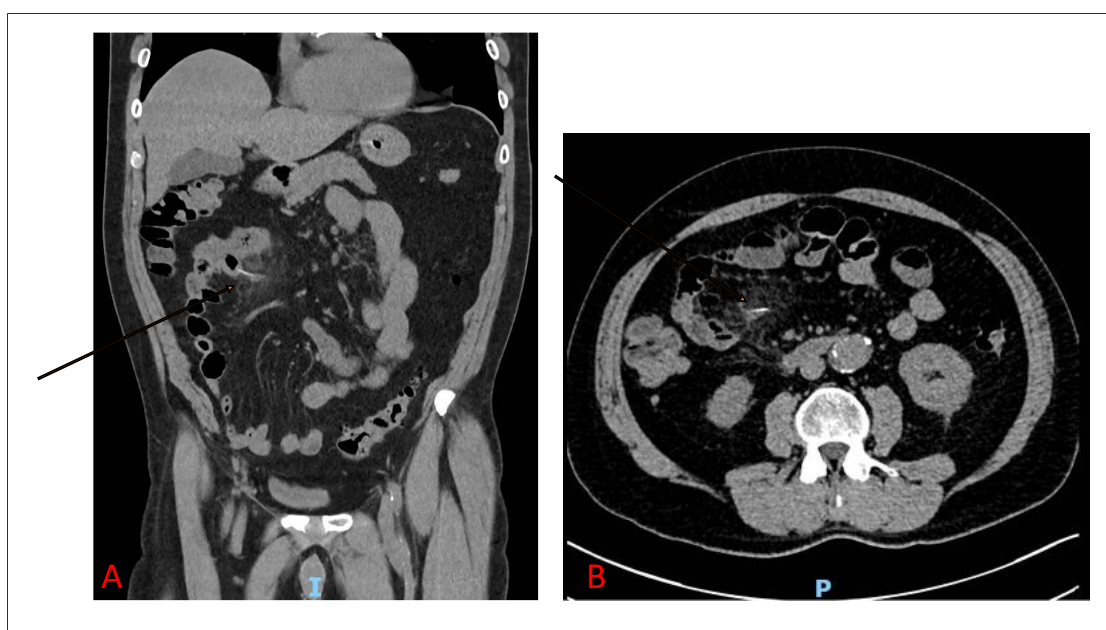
Computed tomography (CT) assessment of the ingested foreign body
